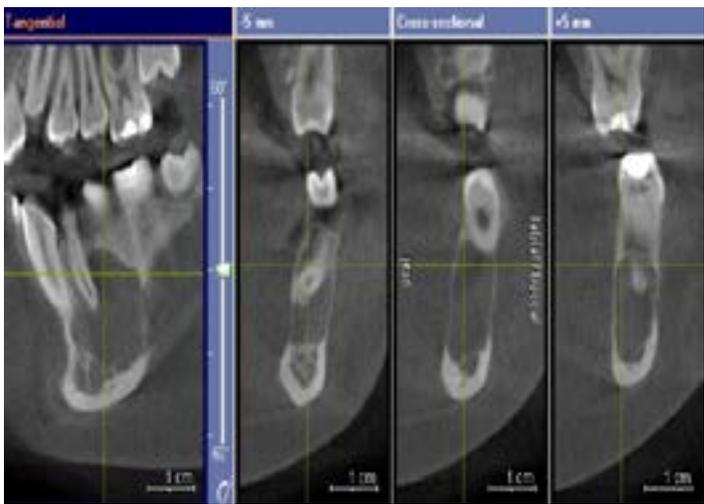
In CBCT it was stated that the lesion caused mandibular expansion, especially marked in towards the vestibule, with thinning of buccal and lingual cortex, but did not cause resorption of the roots of the first and second premolars.
